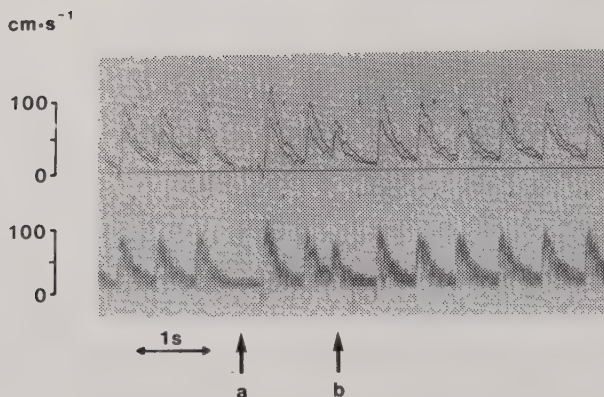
Blood velocity signals recorded from the descending thoracic aorta of a fetus with supraventricular extrasystoles. The extrasystoles are recorded as a missing beat (arrow a) and an extrasystolic beat (arrow b). Doppler shift spectrum in the lower part, analogue signals of the estimated maximum and mean velocity in the upper part.
